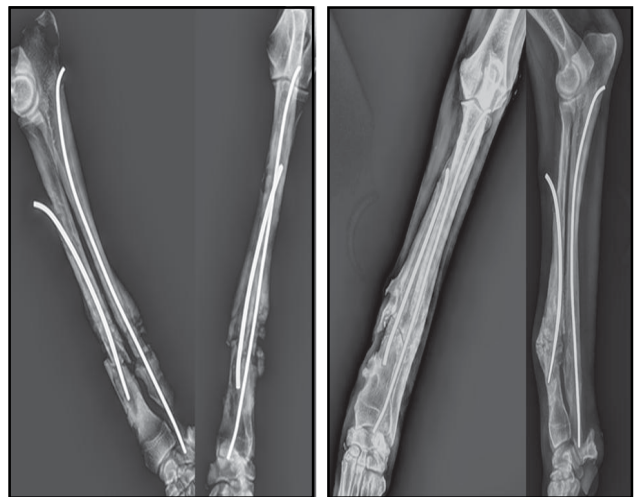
Pre- and post-operative radiographic findings of radius-ulna fracture in case RU2
